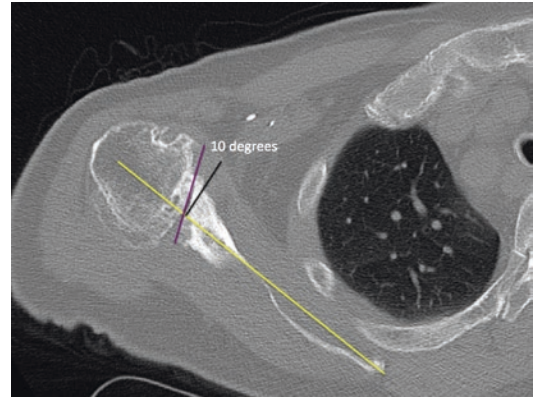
Axial CT in bone windows of the right shoulder shows assessment of glenoid retroversion. The angle is formed between a line perpendicular (black) to a line (yellow) drawn from the medial border of the scapula to the glenoid center and the line (purple) along the glenoid face. In this patient, the glenoid is retroverted by 10°. Also seen is severe narrowing of the glenohumeral joint space with subchondral sclerosis and subchondral cystic change
